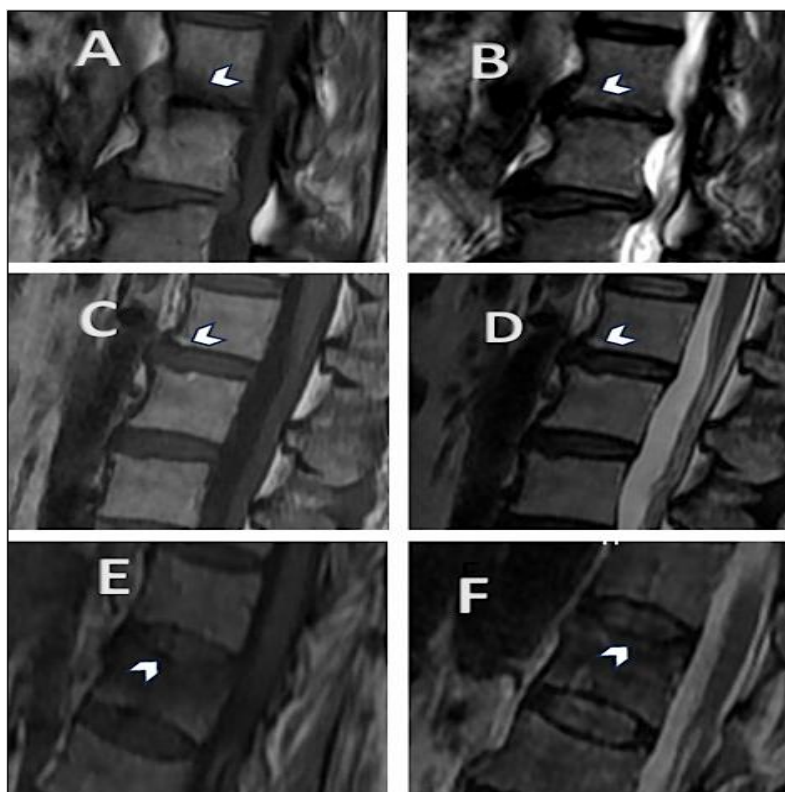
Modic Endplate Changes (Arrows) Assessed on T1- And T2-Weighted Sagittal MRI. (A and B) Type 1 Changes: Hypointense on T1 And Hyperintense on T2, Consistent with Bone Marrow Oedema and Inflammation, (C and D) Type 2 Changes: Hyperintense on T1 And Iso- To Hyperintense on T2, Reflecting Fatty Replacement of Bone Marrow, (E and F) Type 3 Changes: Hypointense on Both T1 And T2, Indicating Subchondral Bone Sclerosis
